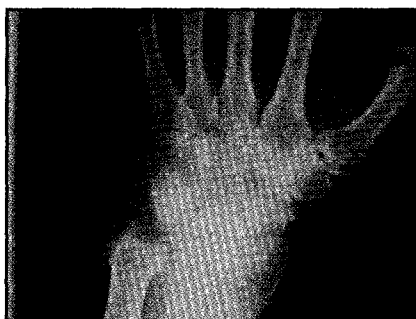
X-rays of the wrist demonstrating joint space narrowing and erosion of the ulnar styloid. Note also mid-carpal erosions.
